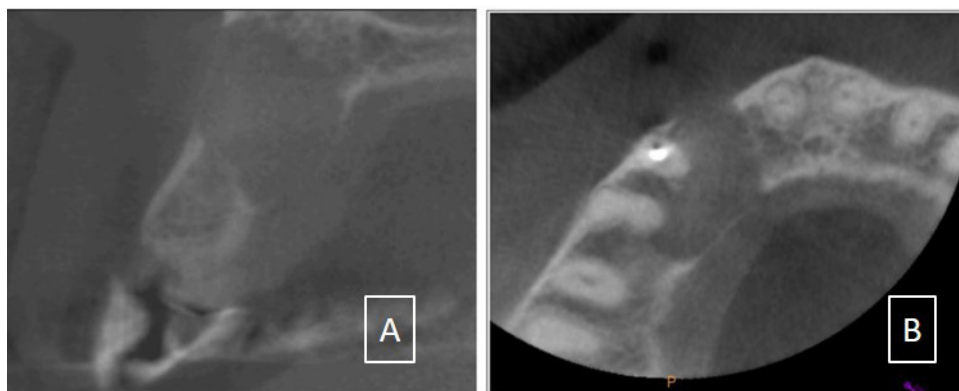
Coronal view between teeth 13 and 12 and axial view of the October 2015 CBCT showing loss of the buccal and palatal cortices.
